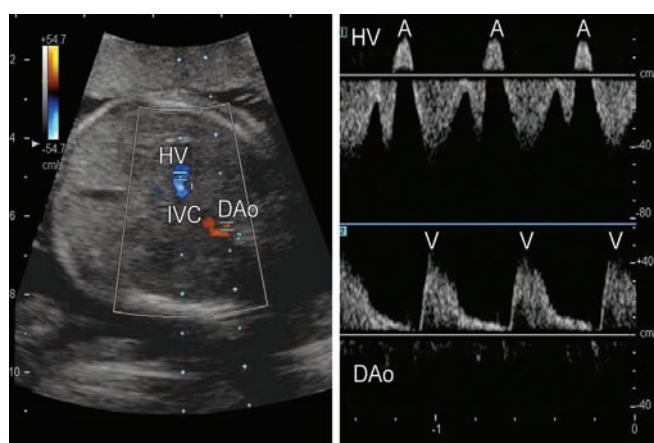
Dual Doppler recordings of the HV and DAo from a normal fetus. Right; one sample gate is placed over one of HVs about 5 mm from the inferior vena cava (IVC), and another gate is placed over DAo. Left; Doppler waveforms in HV (above) and DAo (below). The reversed atrial systolic flow in HV (denoted by A) and the ventricular systolic flow in DAo (denoted by V) can be assessed
